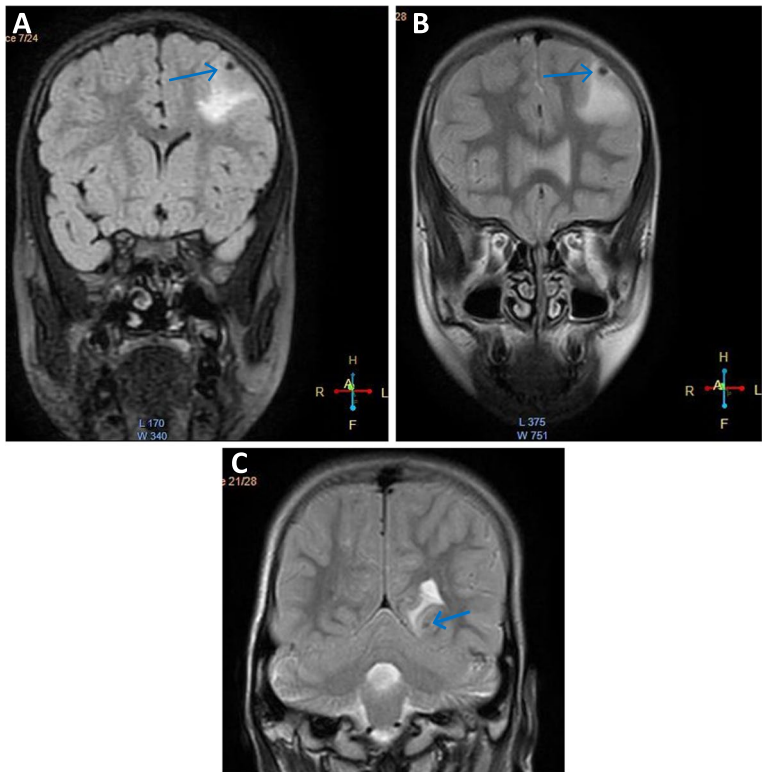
FLAIR (A), T2 (B, C) shows multiple hypo intense cysts of NCC in granular-nodular stage with some perilesional oedema
